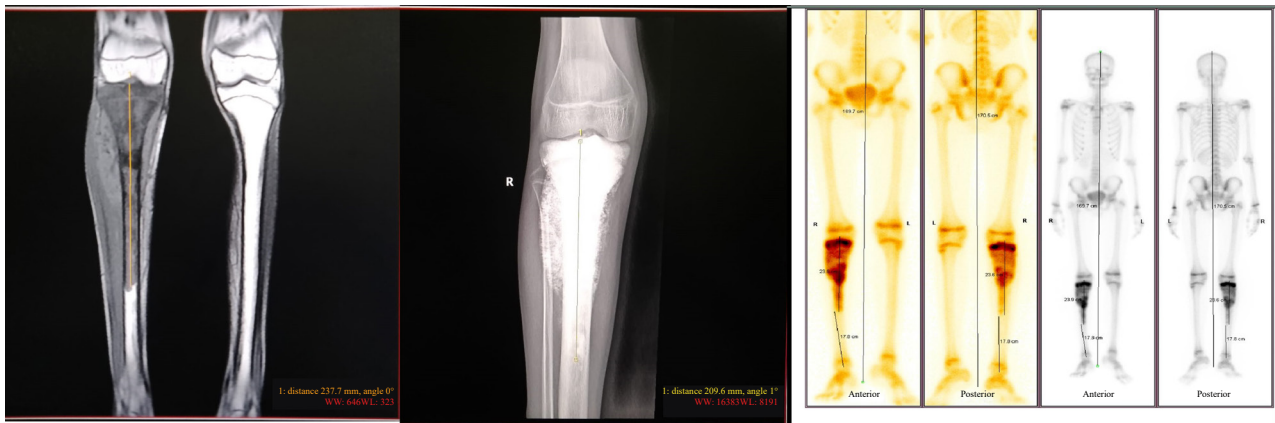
Tumor measurement in tibia - MRI, DR and BS
